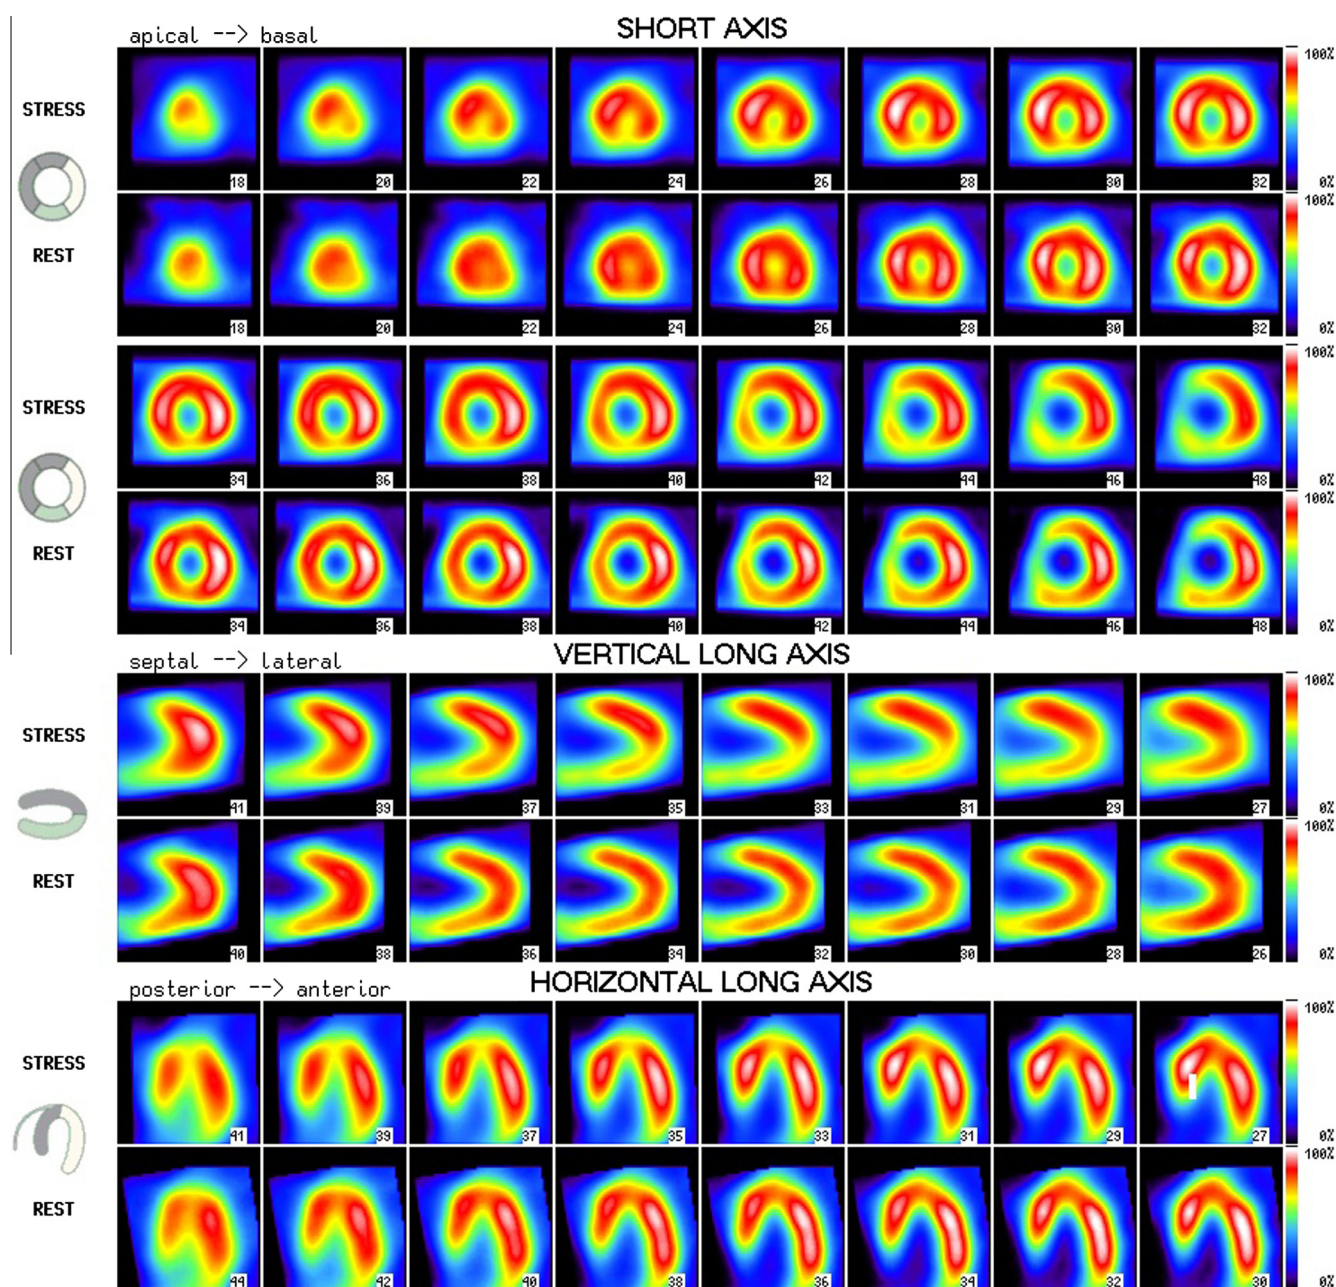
Reconstructed myocardial perfusion SPECT images reveal no significant reversible ischemia.
